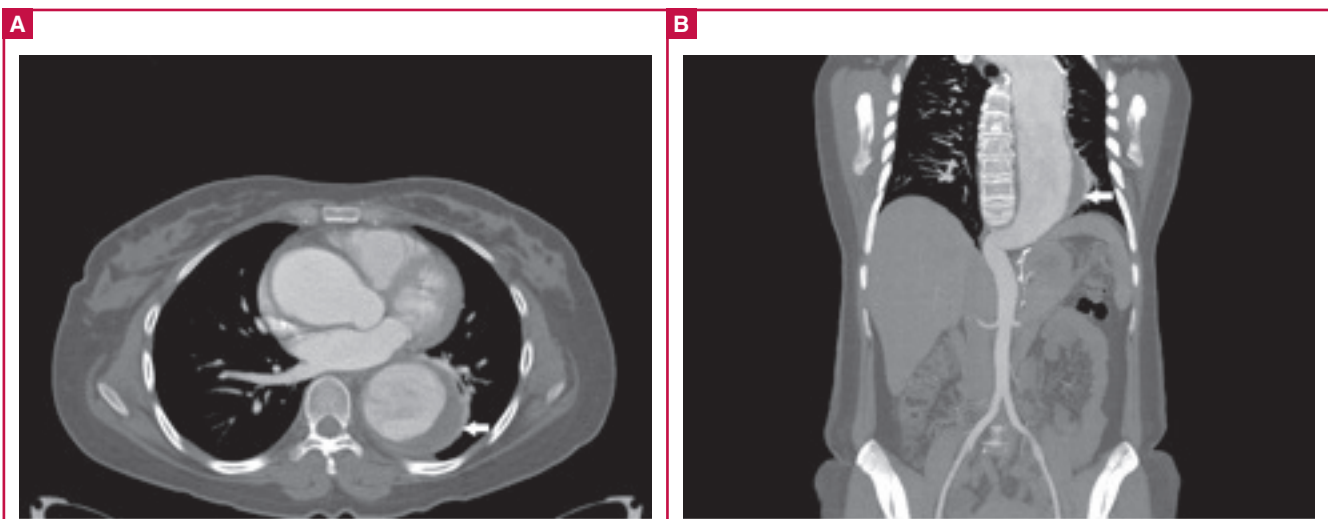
Post-contrast CT images (A) in the axial post-contrast venous phase and (B) coronal curved reconstruction in the arterial phase demonstrating marked thickening of the wall of the thoracic aorta (arrows). Note the involvement of the thoracic aorta only, with sparing of the abdominal aorta.
